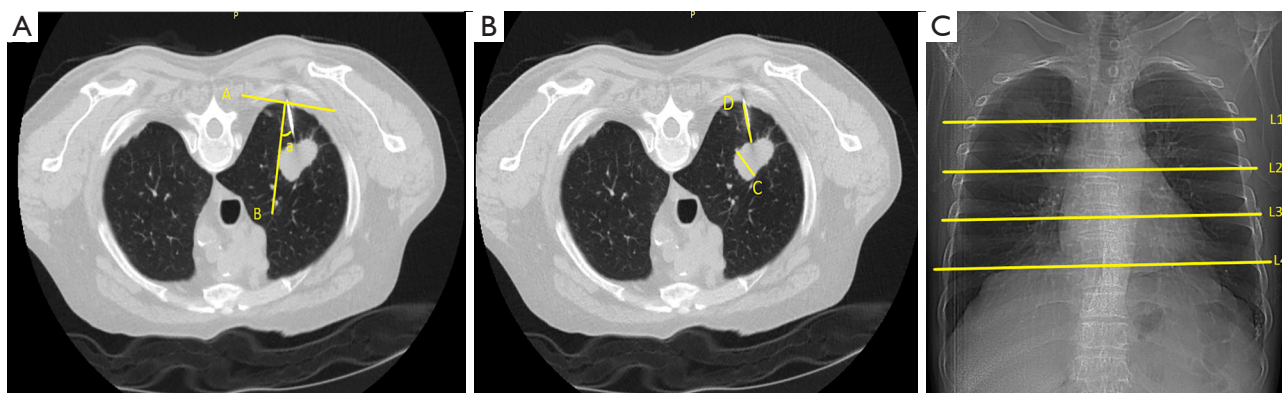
Image in a 77-year-old male patient shows a mass in the right upper lobe. The patient was placed in the prone position for his biopsy and the lesion approached the posterior chest wall. An axial nonenhanced CT image (lung window) acquired during the biopsy demonstrates that an 18-gauge coaxial needle positioned adjacent to the lesion. (A) Line A is the tangent line of the pleura at the puncture point, line B is perpendicular to line A, and the angle a between line B and the needle represents the needle insertion angle. (B) The length of line segment C represents the short diameter of the maximum cross-section of the lesion, and the length of line segment D represents the distance from pleura to lesion. (C) L1, L2, L3 and L4 divide the lung field into five equal sections on the chest radiograph, with upper, upper-middle, middle, lower-middle, and lower lung field from top to bottom. The mass was in the upper lung field on the chest radiograph.
